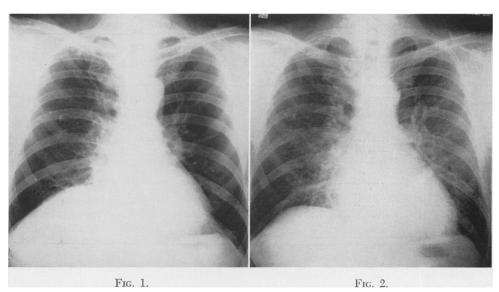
Roentgenogram of the chest obtained February 26, 1952. The heart is not enlarged. There is minimal tuberculosis in the apex of the right lung. The right diaphragm is elevated. FIG. 2. Preoperative roentgenogram of the chest obtained May 19, 1952. The minimal tuberculosis at the right apex is essentially unchanged. There has been a slight increase in the transverse diameter of the heart and increased vascularity in the lung fields.
